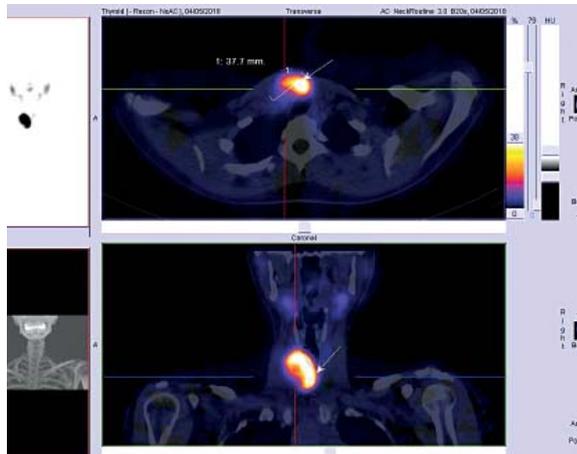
m99 Tc SPECT CT scan showing a toxic adenoma in the right lobe of the thyroid gland
